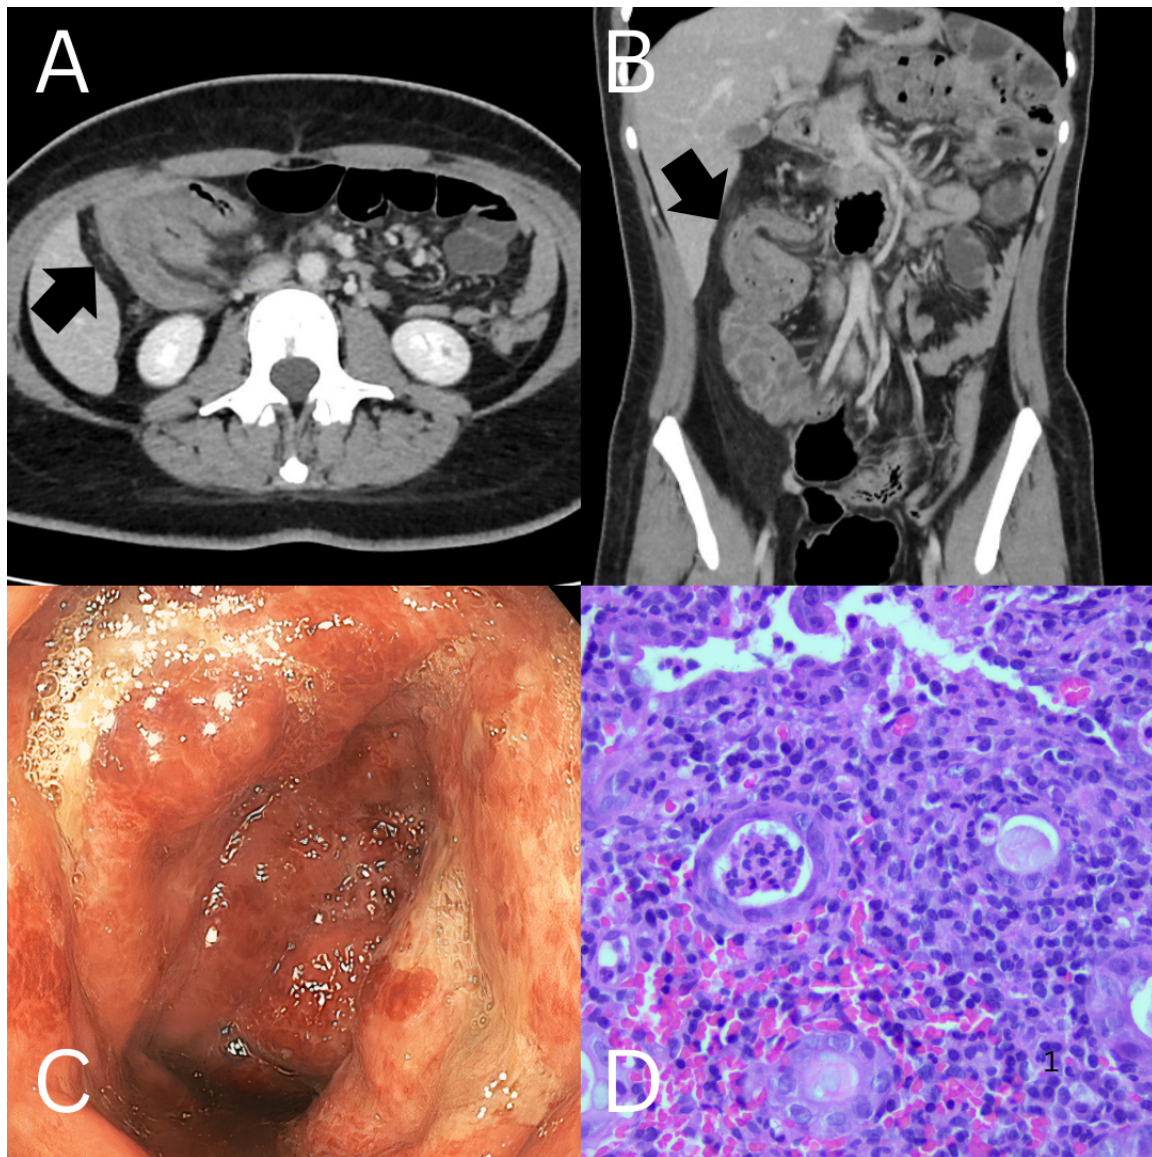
and 1B. Abdominal CT demonstrates inflammatory thickening of the right colon with features suggestive of colo-colonic intussusception. Figure 1C. Colonoscopy reveals intussusception of the ascending colon. Figure 1D. Colonic biopsies show focal cryptitis, crypt microabscesses, and intramucosal lymphoid aggregates.
